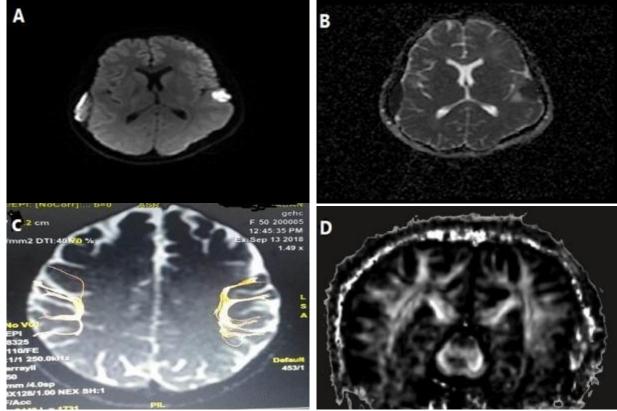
Female patient aged 50 years, there was no medical history of hypertension or diabetes, the patient was presented with global aphasia. (A) and (B) DWI and ADC map showed: Bilateral cortical areas of recent infarction were seen in parietal regions. (C) Diffusion tensor tractography showed: reconstruction of the FA fibers in both sides. (D) Fractional anisotropy (FA) map showed: reconstruction of the FA fibers in both sides, this patient had AHS of 1.92.
